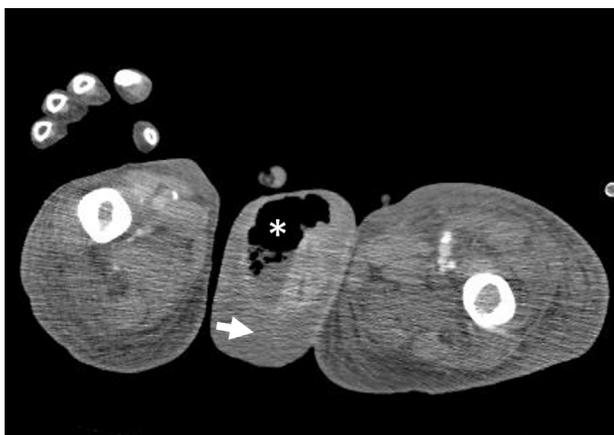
CT of the pelvis (transverse plane) at the level of the scrotum, showing subcutaneous emphysema (asterisk) with adjacent fluid accumulation (arrowhead).
